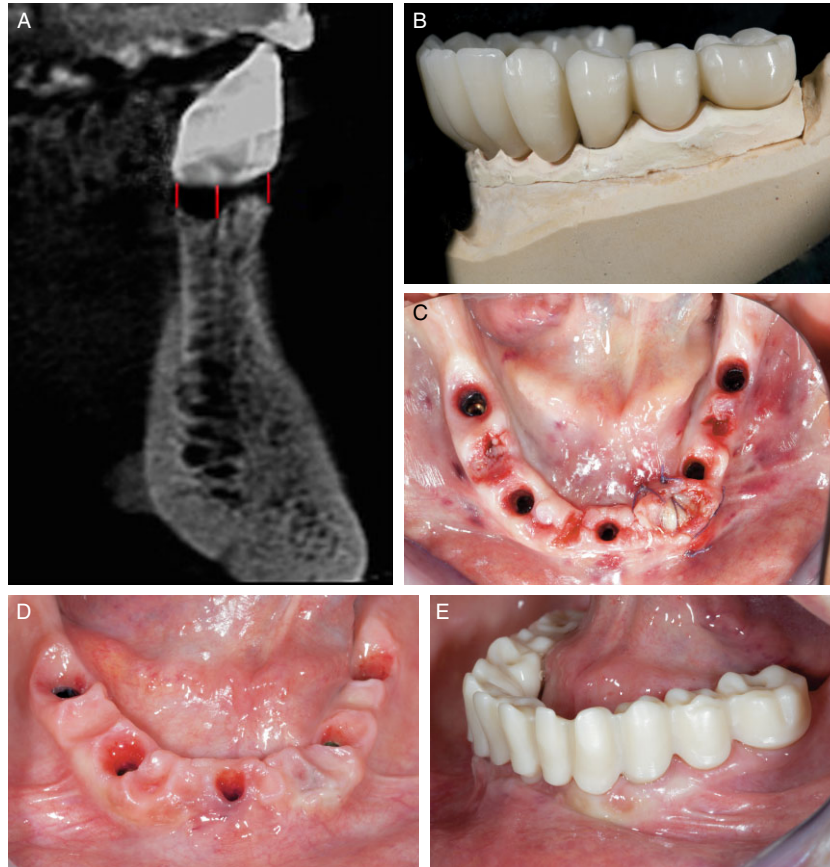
A: 2CBCT 2D cross-sectional view at the mid-pontic unit with the three measurements taken at the facial and palatal/lingual aspects. CBCT=cone-beam computed tomography. B: Temporary restoration contoured with BPD concepts. C: The recipient sites were reconfigured in order to house properly the pontic contour leaving 2 mm of clearance between the provisional and the underneath bone tissue; the lack of keratinized tissue has been compensated with a connective tissue graft. D: The soft tissue reshaping after 3 months of healing. E: The anatomic contoured ZIBR with the pontic sites embedded in the anatomically reshaped soft tissue.
